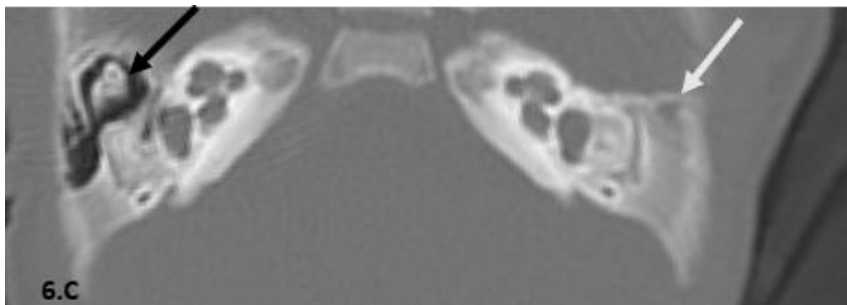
C: Axial CT view, bone window revealed normal right middle ear cavity and ossicular chains (black arrow), left side absent middle ear cavity (white arrow).
